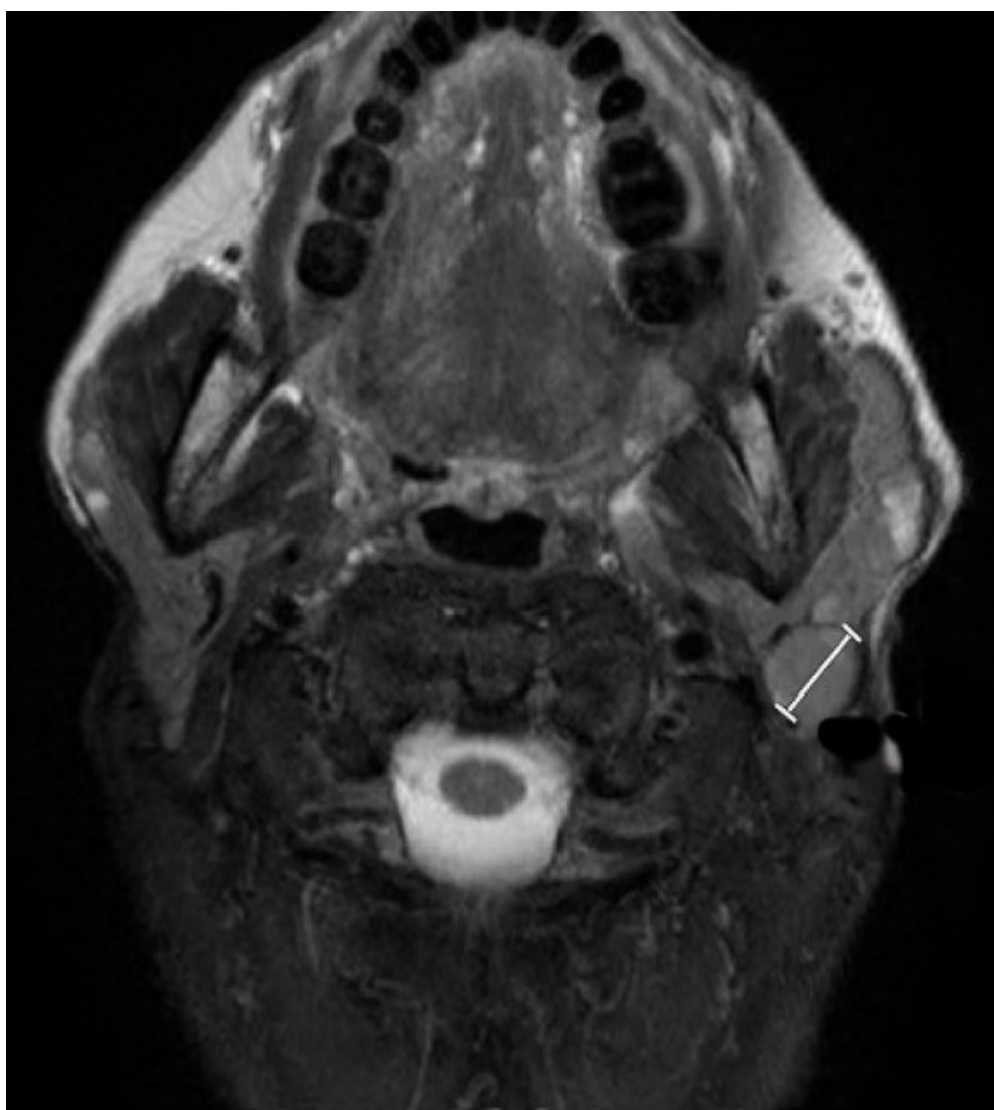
Image of a parotid salivary gland cyst on an MRI slice. Within the location of the lower pole of the gland, a formation measuring 2x2 cm is visualized.
